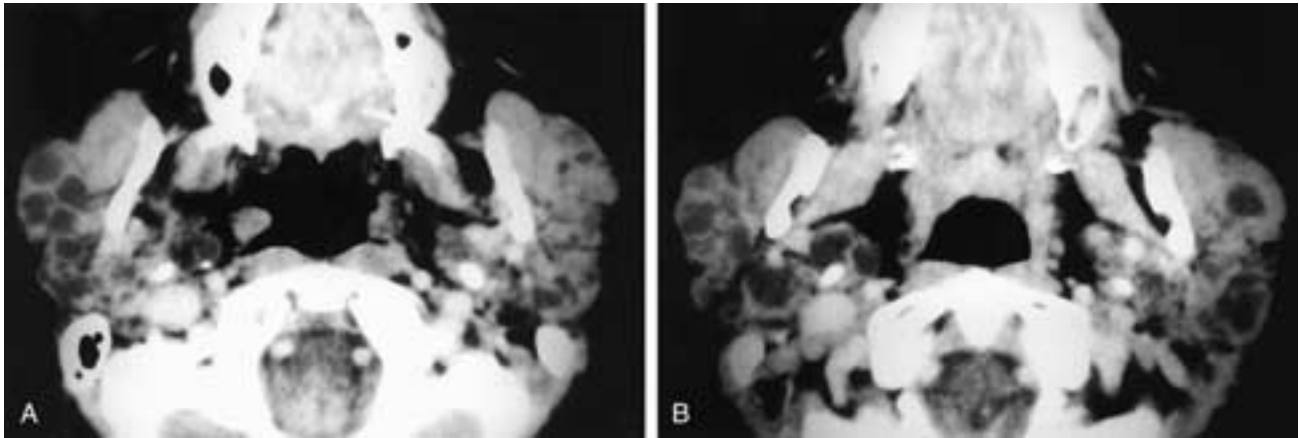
Axial contrast-enhanced CT scans (A, B) show multiple bilateral parotid cysts of varying size. The parotid parenchyma is denser than normal, and the parotid glands are slightly enlarged. This patient had end-stage cystic changes of autoimmune disease (SS).
